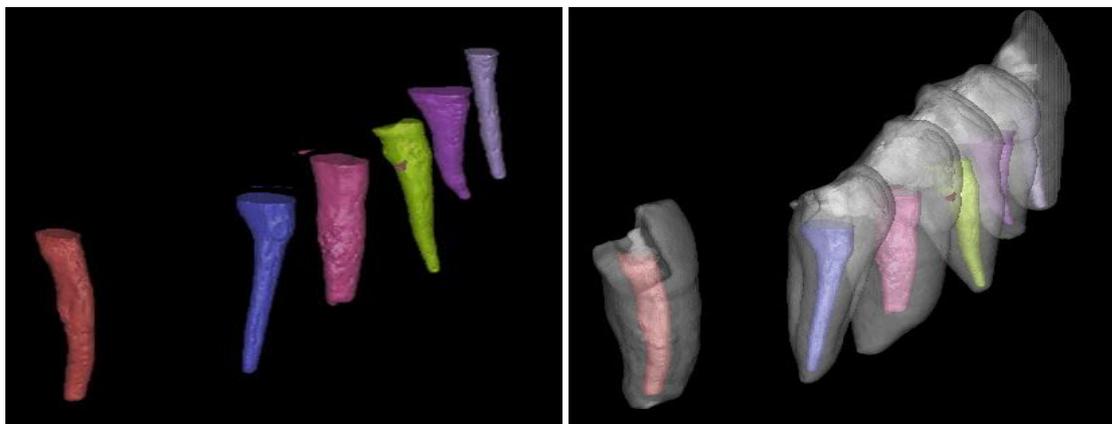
Showing CBCT scanning of root canal filling using MTA filling technique.
